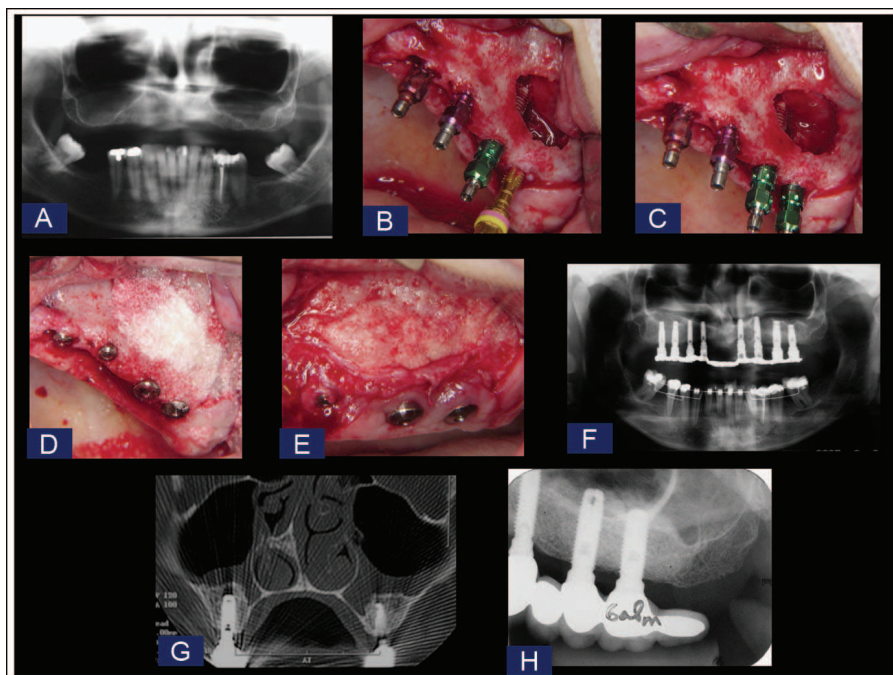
Left sinus aspect of a bilateral atrophic maxilla reconstruction. Panoramic view: base line subsinus bone (A); 3.25 screw tap (B); threaded implants well positioned (C); external SBRG layer (D); lateral wall aspect after 11 months (E); panoramic view with temporary rehabilitation (F); sinus CT view after almost 7 years (G); and intraoral x-ray (H).
